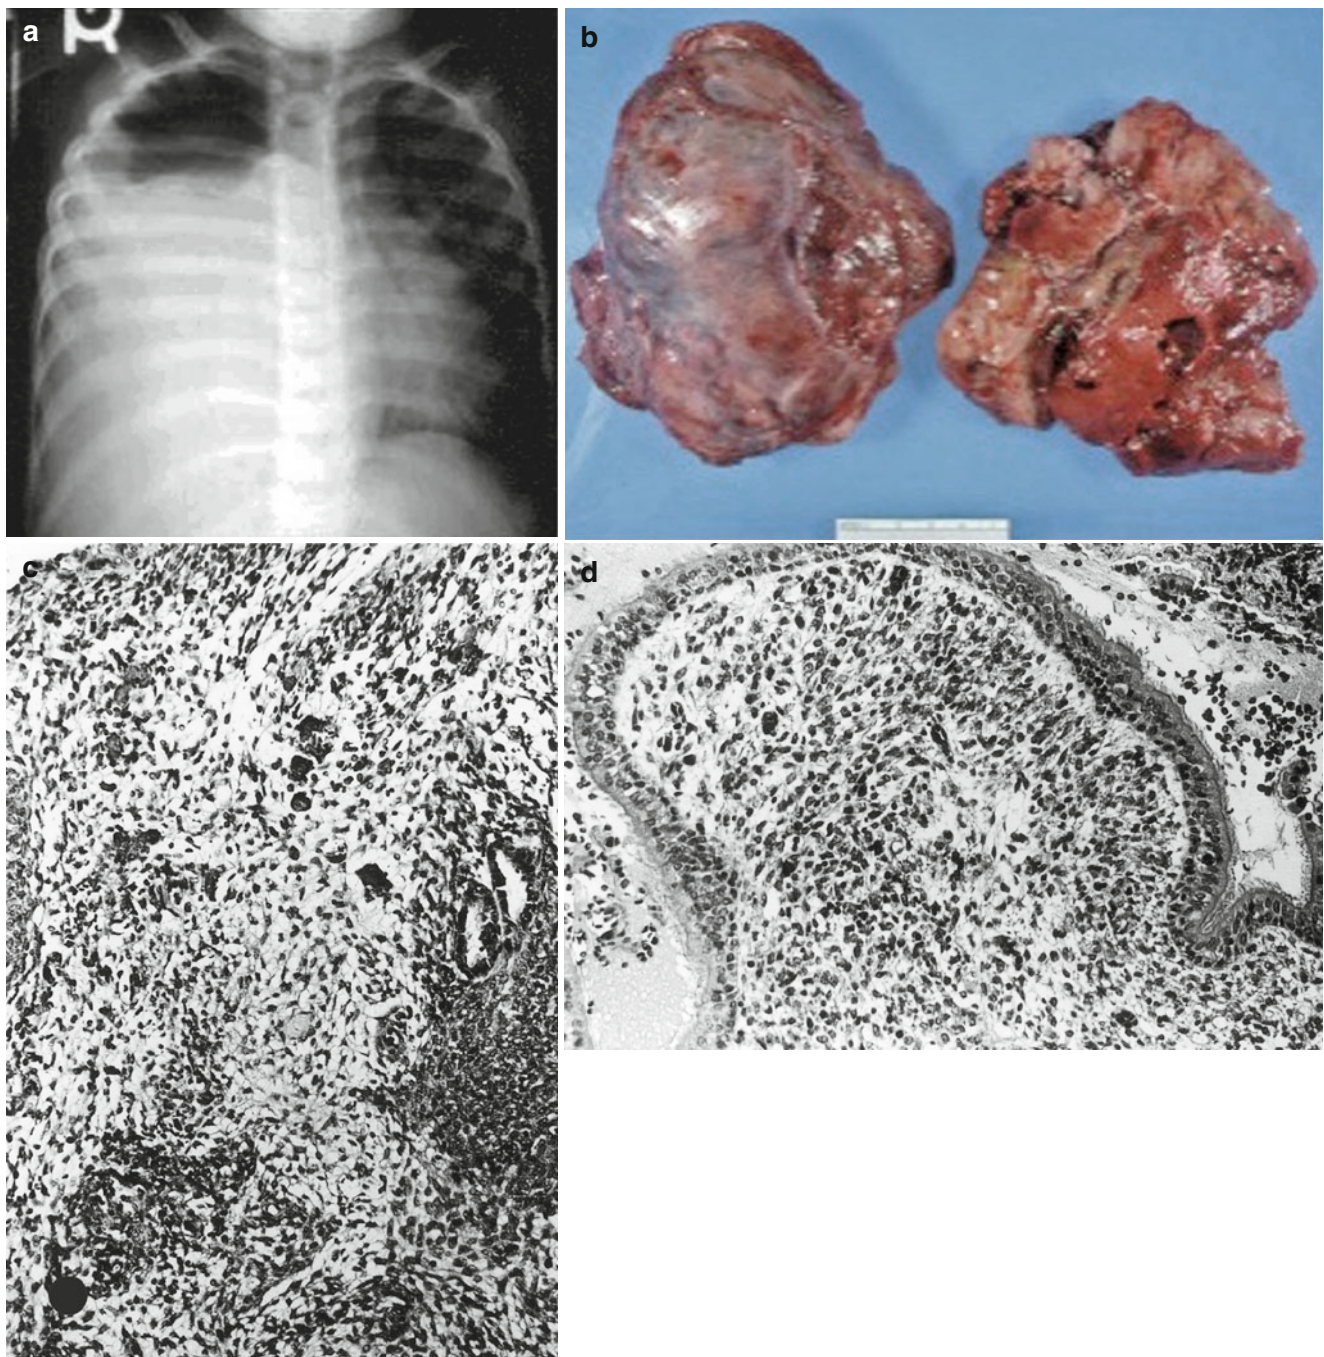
Pleuropulmonary blastoma. Two-year-old female with progressive respiratory distress and low-grade fever. (a) Chest X-ray, pulmonary blastoma showing opacification of the right hemithorax (“whiteout”). (b) The tumor is light tan-gray, friable with extensive necrosis and hemorrhage. (c) Blastemal (darkly cellular) areas alternate with pale, myxoid
